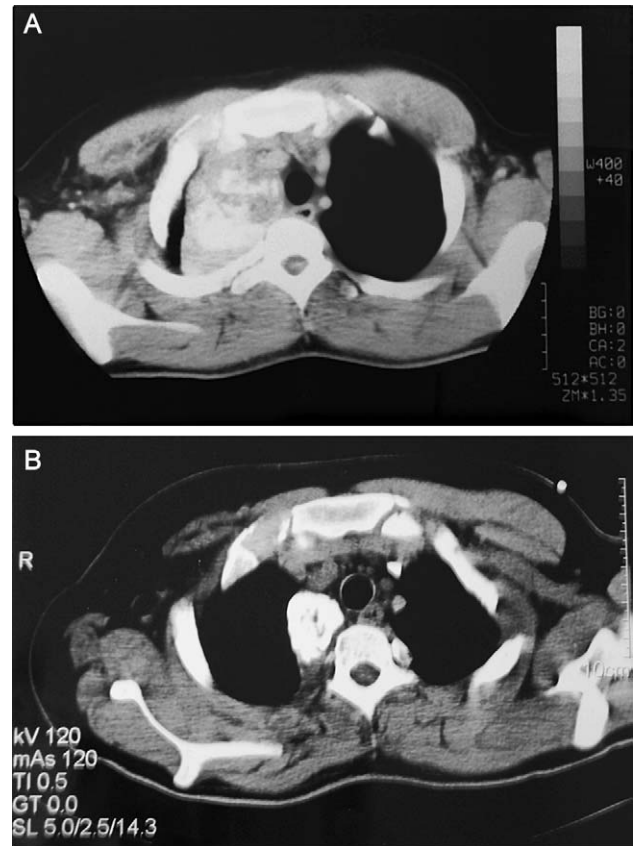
(a) Computed tomography of the thorax showing a tumour mass located at the right lung apex; (b) computed tomography of the thorax carried out 2 months after induction chemotherapy and high-dose chemotherapy, showing a calcified residual tumour mass located at the right lung apex.
